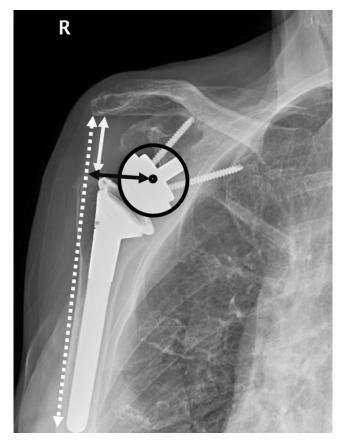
Radiographic measurement technique. The *solid white line* demonstrates the acromial–greater tuberosity distance (AGT), a measure of humeral distalization, which was measured as the shortest distance between the greater tuberosity and the acromion. The *dashed white line* shows the line of pull of the deltoid, and the *solid black line* shows the medialization of the center of rotation relative to the line of pull of the deltoid (CORM), which was measured as the distance between the center of the best-fit circle of the humeral head or glenosphere on preoperative and post-operative radiographs and a line between the most lateral aspect of the acromion and the deltoid tuberosity
